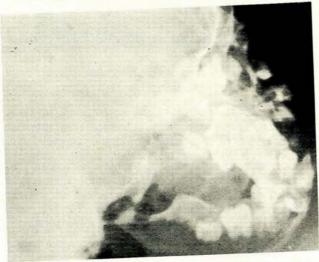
X-ray of the teeth showing irregularly deformed tooth roots.
